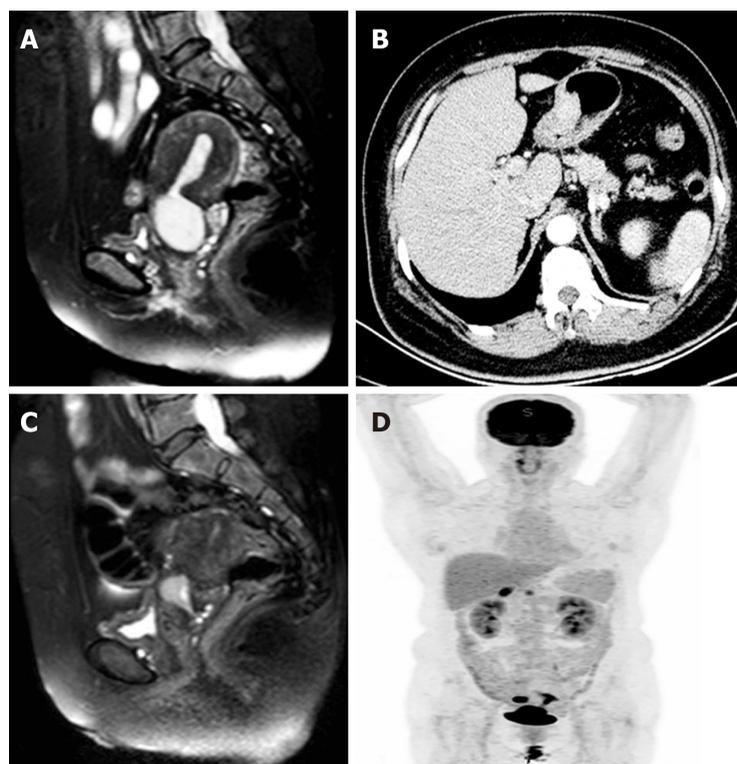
Imaging findings of the patient. A: Pre-chemotherapy magnetic resonance imaging (MRI) scan showed a solid mass located in cervical canal of uterus, suspected involvement of rectal wall; B: Thickened gastric wall was suspected malignant on computed tomography (CT) scan; C: Postchemotherapy MRI scan showed a decreased solid mass located in cervical canal of uterus; D: Abnormal fluorodeoxyglucose uptake in the cervix uterus, uterine cavity, right adnexa as well as in the stomach on positron emission topography/CT scan.
